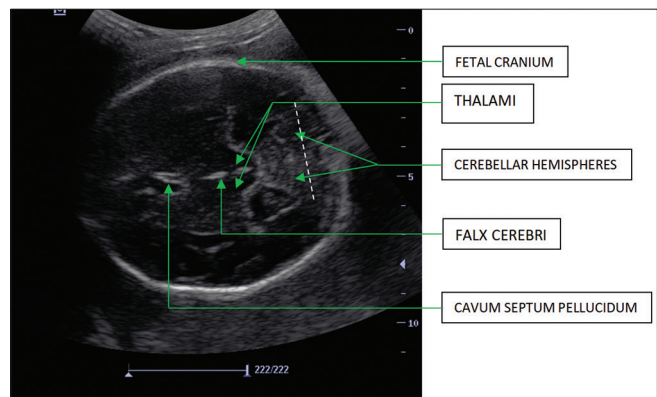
B-Mode transaxial sonographic appearance of Grade IIIb cerebellum at 35 weeks GA showing triangular or fan-shaped cerebellar hemispheres with the cerebellum now looking more solid than cystic. GA: Gestational age
